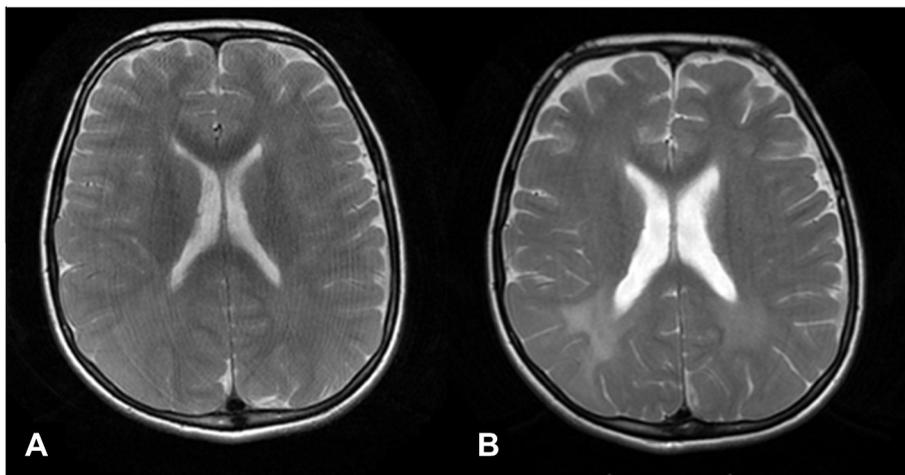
The first normal MRI (A) and T2 weighted axial section showing hyperintense lesions of both parietal areas in cerebral white matter during follow-up period (B).
